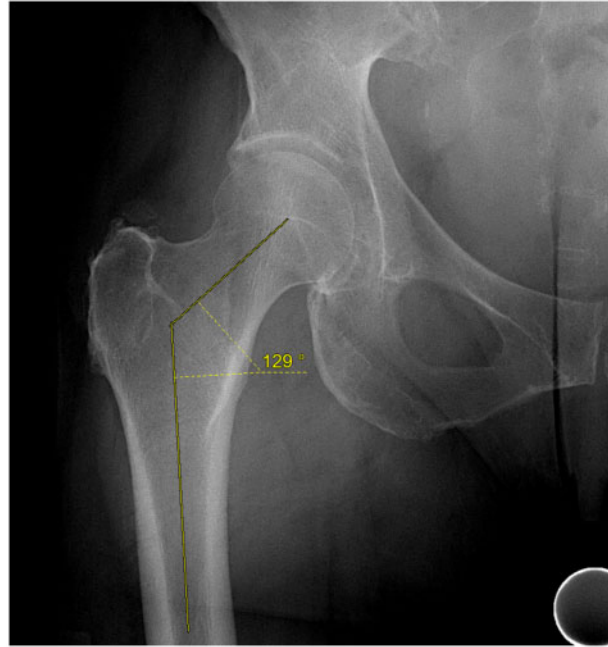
NSA is 129 degrees as measured on the right hip AP X-ray image.
